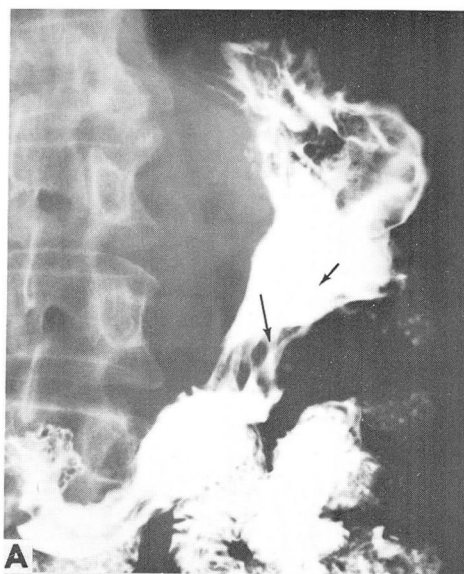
A, Roentgenogram, after conventional barium swallow, showing suspicious deformity (arrows) along the greater curvature. B and C, The triple-contrast study of the stomach (barium spray combined with pneumoperitoneum). B, Normal thickness of the wall of the body of the stomach is delineated by arrows. C, Selective view of the wall of the greater curvature of the stomach, showing the cobblestone appearance of gastritis, but no evidence of infiltrating tumor.
